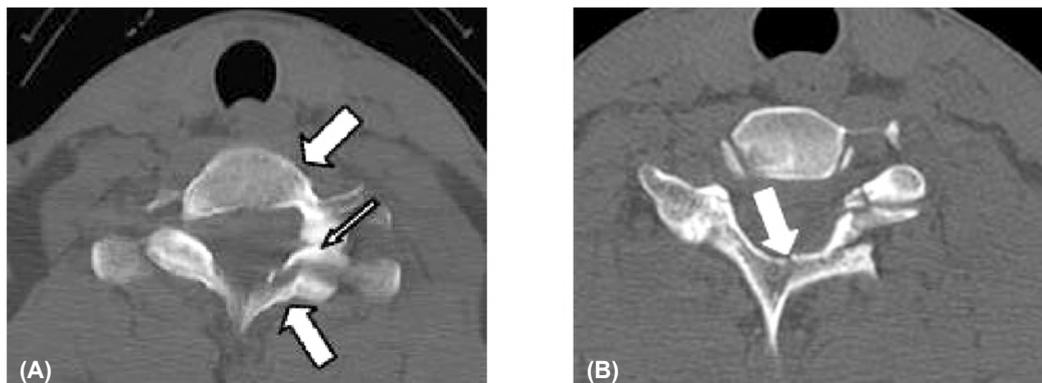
CT-scan demonstrating a left fracture-dislocation C7-T1 (small arrow in upper image), the two large arrows point to the vertebral body and to the lamina.
